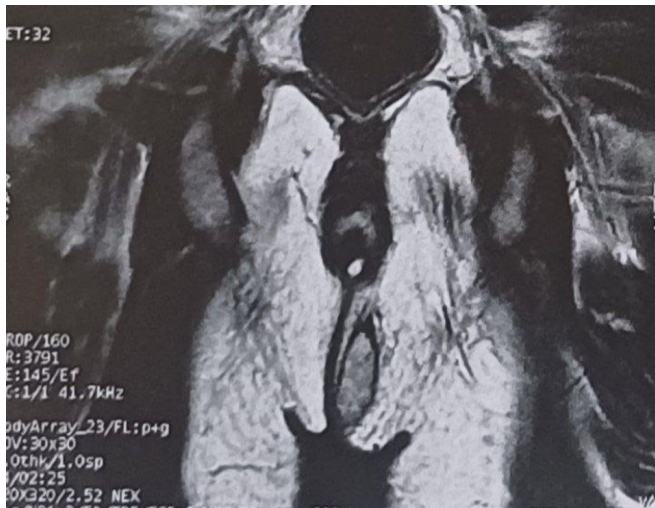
Pelvic MRI image showing the mass
